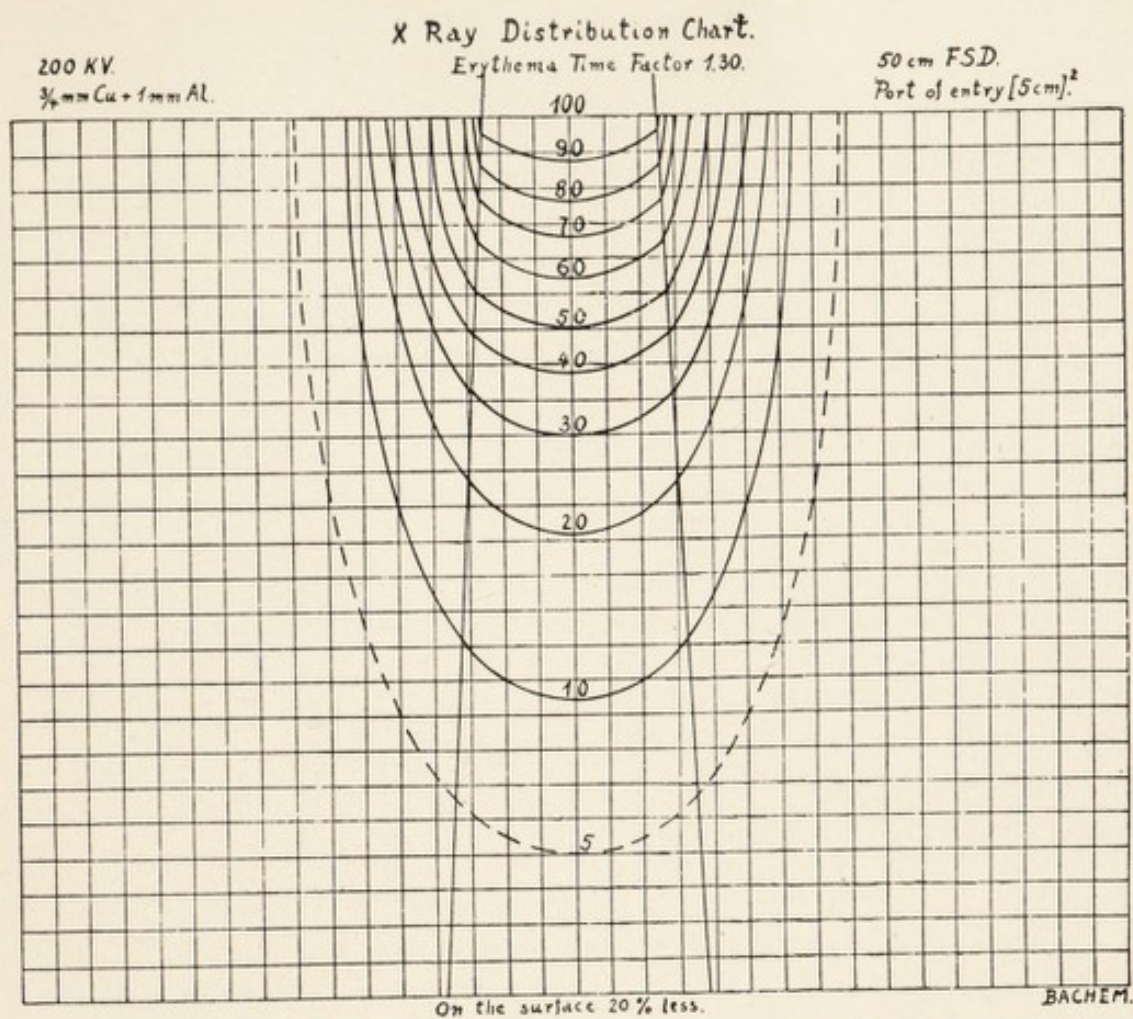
X-RAY EQUAL INTENSITY CURVES IF PORT OF ENTRY IS 5 CM.<sup>2</sup>
